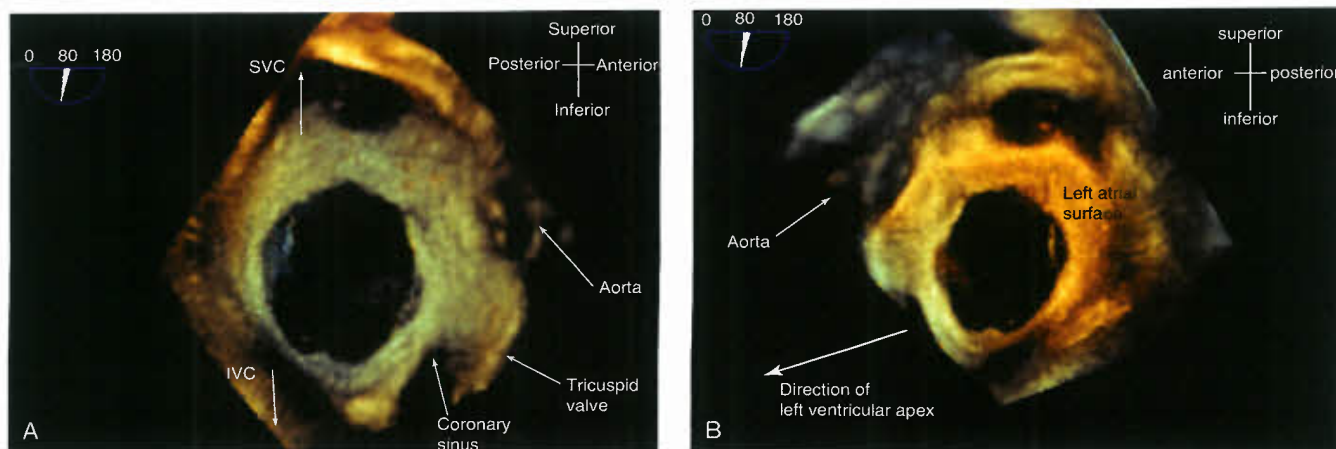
Three-Dimensional transesophageal echocardiogram. A: Right atrial view of secundum ASD. B: Left atrial view of secundum ASD. IVC, inferior vena cava; SVC, superior vena cava. (From Pushparajah K, Miller OI, Simpson JM. 3D echocardiography of the atrial septum: anatomical features and landmarks for the echocardiographer. *JACC Cardiovasc Imaging*. 2010;3:981–984, with permission).
